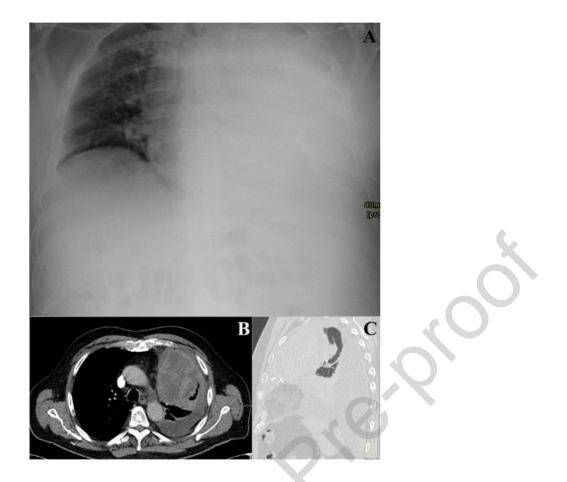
A Anteroposterior chest X-ray at hospital admission shows a complete "white out" of the left hemithorax. There is a slight deviation of the mediastinal structures to the contralateral right side. B-C Chest CT 4 days later, after placement of a chest tube. B Axial CT image (soft tissue window) shows a heterogenous mass in the upper left lung abutting the pleura. Note also a left pleural effusion. C Sagittal reformatted CT (lung window) shows almost complete collapse of the left lung.
